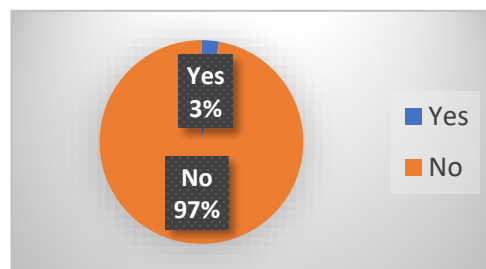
Does your office/court require the screening of all subsequent DWI offenders?
